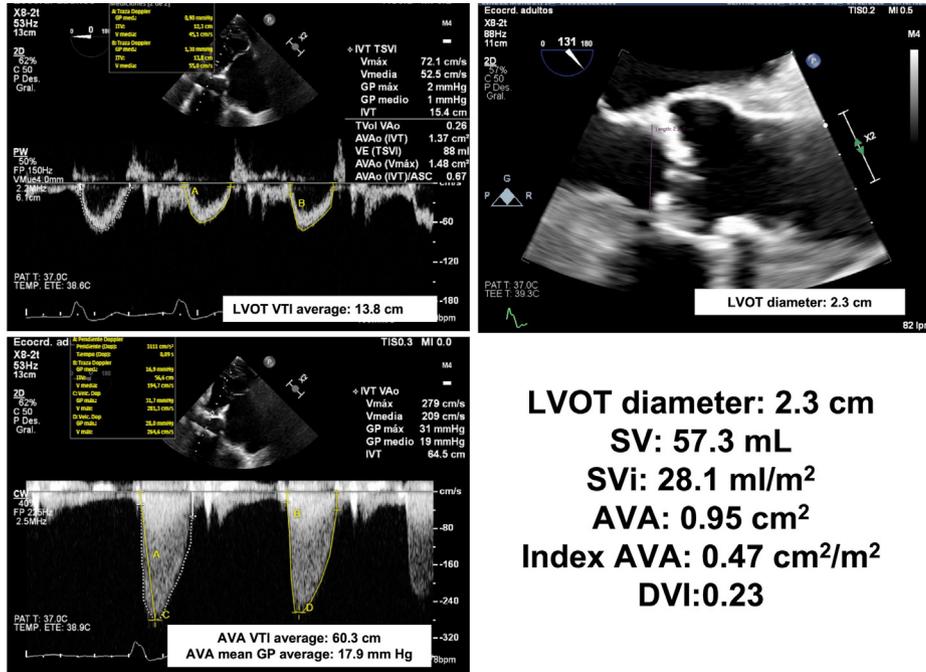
Two-dimensional TEE-guided pulsed-wave (*top left*) and continuous-wave (*bottom left*) Doppler findings demonstrate average aortic V_{max} of 2.7 m/sec, average MG of 17.9 mm Hg, AVA of 0.95 cm², indexed AVA of 0.47 cm²/m², DVI of 0.23, SV of 57.3 mL, and SVi of 28.1 mL/m². Zoomed apical long-axis image (131°) of the LVOT diameter (*top right*) demonstrating a maximal diameter of 2.3 cm.
